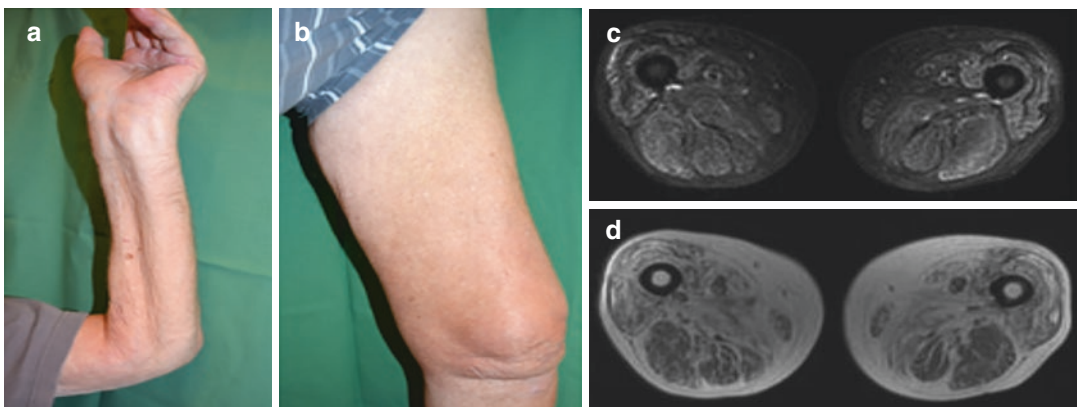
Patient with inclusion body myositis. (a, b) Typical muscle atrophy in forearm and in quadriceps. (c) STIR (short tau inversion recovery) sequence in magnetic resonance imaging of thigh muscles showing persisting inflammation after 4 years of IBM duration. Almost all
